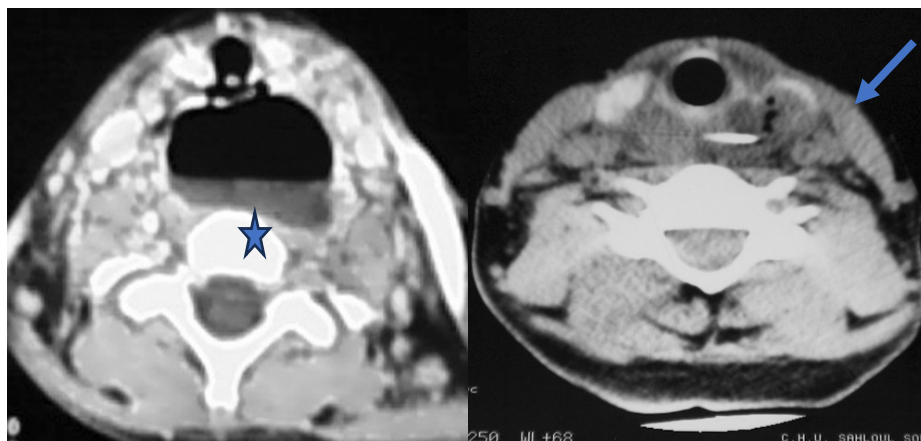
Axial cervico-thoracic CT scan showing features of mediastinitis (a) and a peri-esophageal abscess (b).
